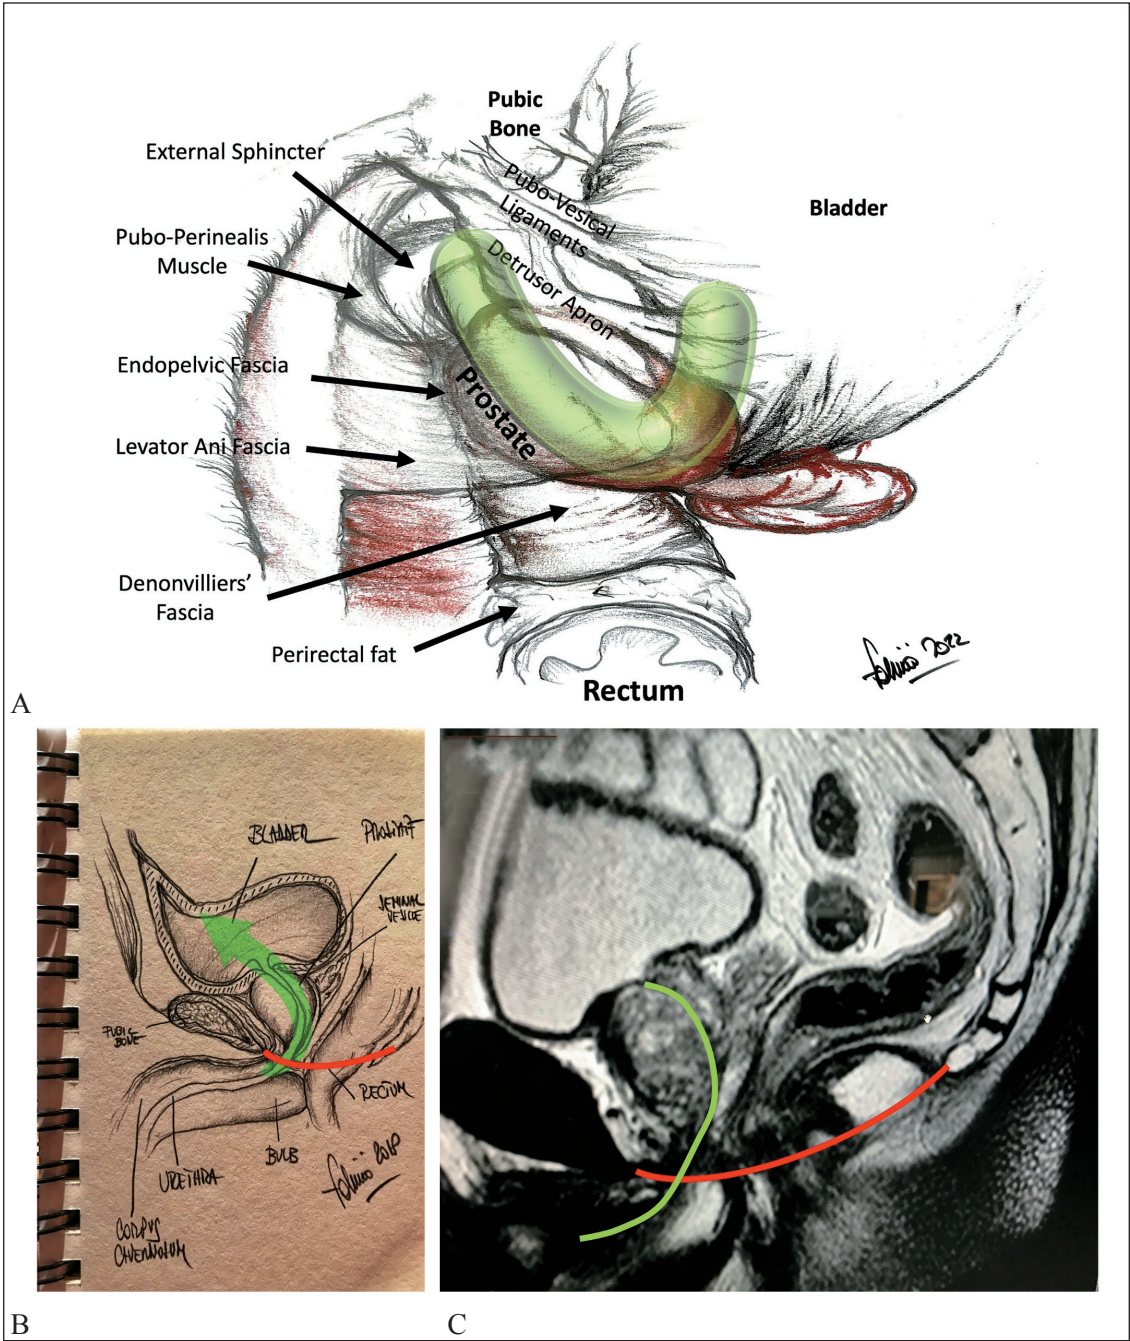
A) Scheme of the supportive structures of the prostate with the natural curve of the urethra (green). B, C) Scheme and MRI view of the normal position and course of the urethra (green) and the perineal floor (red).
